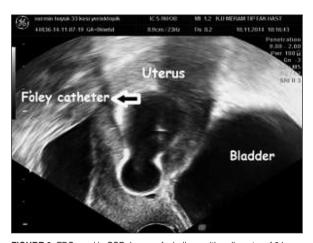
FBC used in CSP. Image of a balloon with a diameter of 34 mm, inflated with 20 ml saline in the sagittal transvaginal ultrasound imaging. Balloon presses the surrounding antero-posterior tissues with its ovoid shape. FBC: Folley balloon catheter; SP: Caesarean scar pregnancy.
